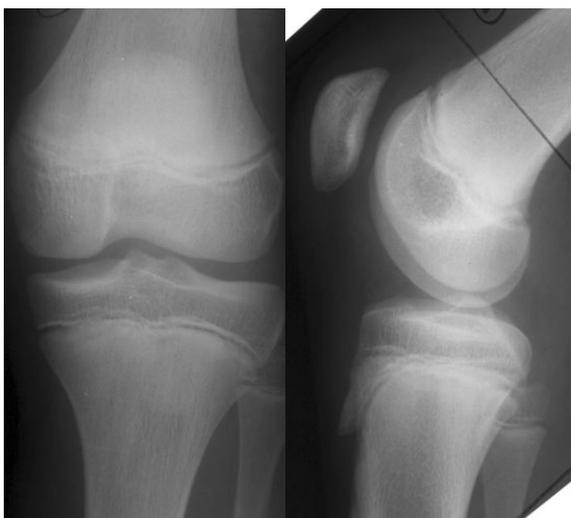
The radiography of a knee joint in direct and lateral projections. The radiography belongs to a child. Zones of metaphysis-epiphysis cartilages in the bones forming a knee joint are detected as stripes of clarification. An ossification kernel is observed in the area of tuberosity of the tibia. Norm.
